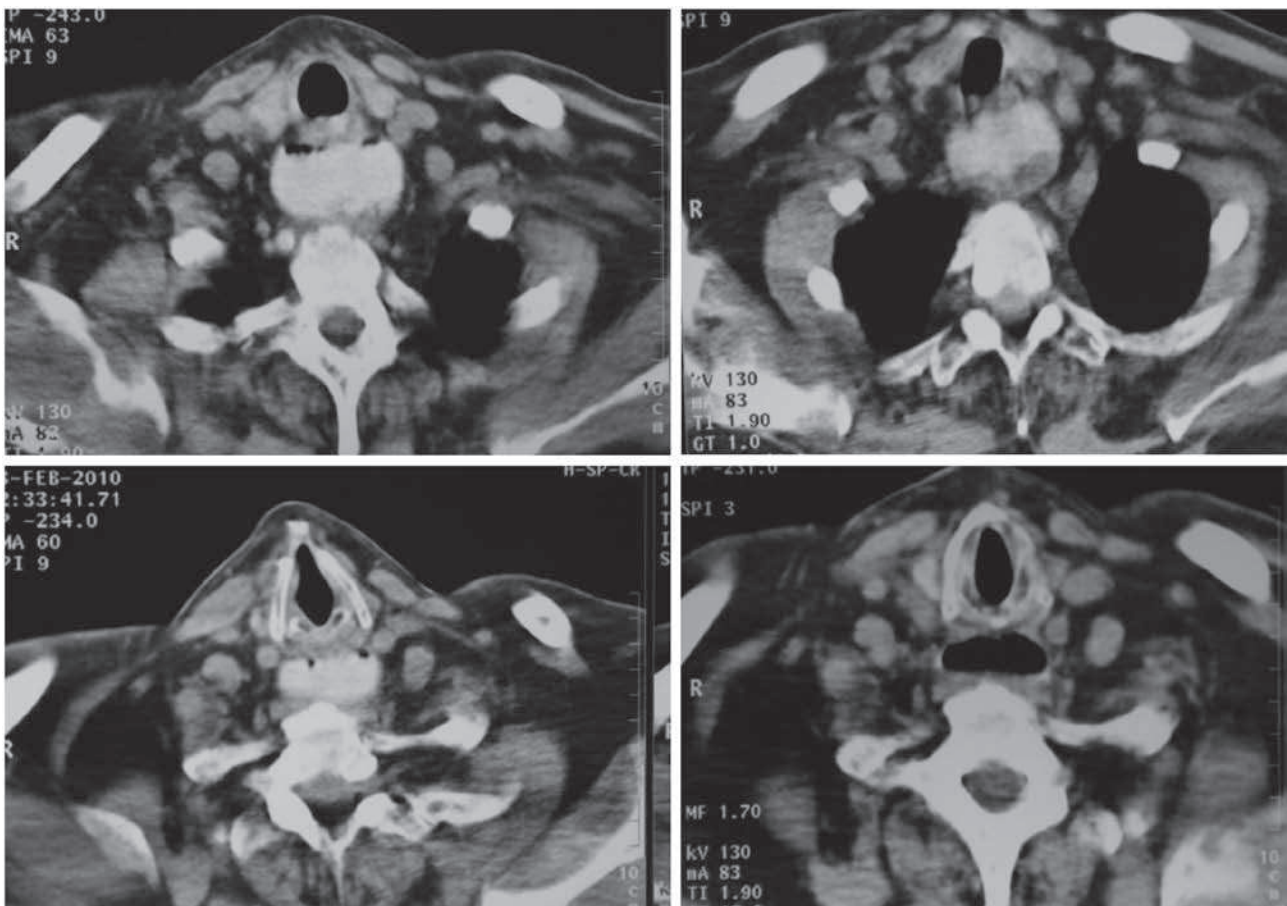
Cervical CT scan of the neck showing Zenker's diverticulum.
